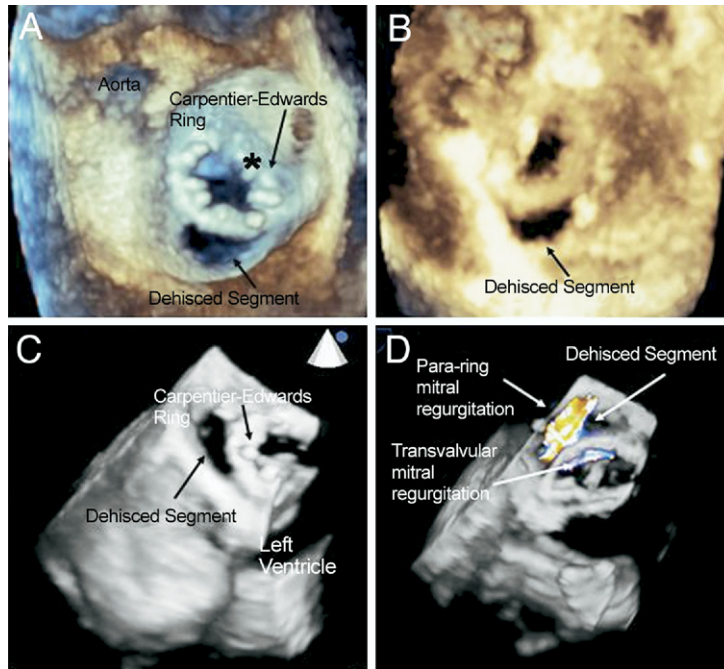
Dehiscid Carpentier-Edwards Ring, Real-Time 3-Dimensional Transesophageal Echocardiography
